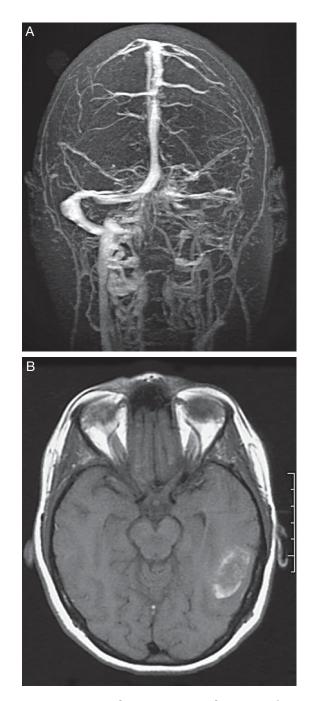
Veno-occlusive Disease and Venous Infarction. The patient was a 47-year-old woman who was taking oral contraceptives. A, Magnetic resonance venogram demonstrates extensive thrombosis of the left transverse and sigmoid sinuses that extends to involve the left internal jugular vein. B, Nonenhanced T1-weighted magnetic resonance image shows hemorrhagic venous infarction in the left temporal lobe.
